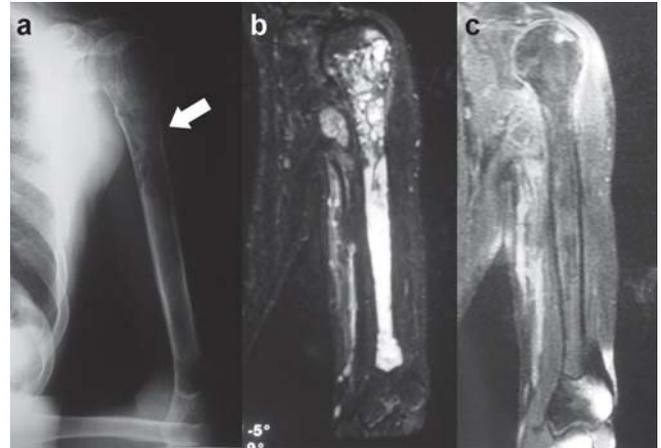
(a) Direct X-ray of the humerus, white arrow shows the pathologic fracture line. (b) Coronal T2 weighted sections of the lesion. (c) Coronal T1 weighted sections of the lesion.
